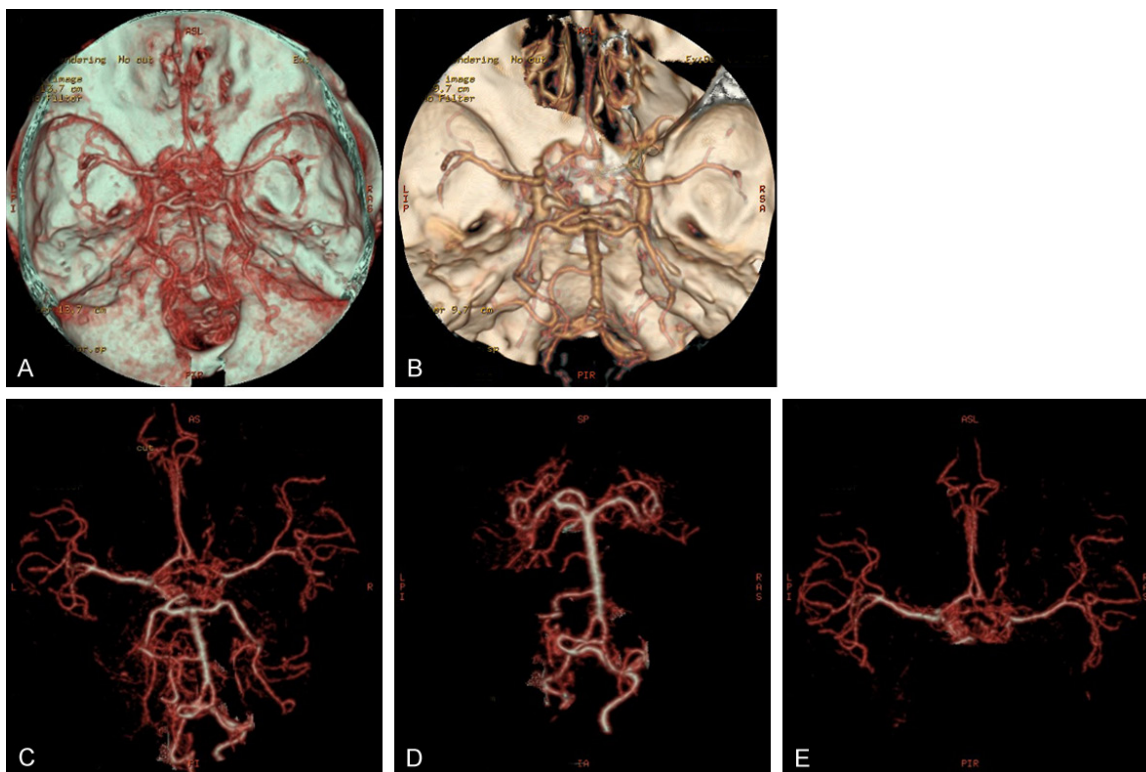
Head CTA images. A-E: The ophthalmic artery segment and the clinoid segment of the bilateral ICA; the communicating segment of the right ICA is not shown, and vessel networks can be observed in sellar region. Fenestration of the right ophthalmic artery is observed. The bilateral vertebral arteries are slightly thinner, and vessel networks are seen above foramen magnum. The bilateral middle cerebral arteries are slightly thinner, and the A1 segment of the right anterior cerebral artery is not shown. The contours of the left anterior cerebral artery, the basilar artery, and the posterior cerebral artery are natural, the images are good, and the lumen does not show significant narrowing or expansion.
